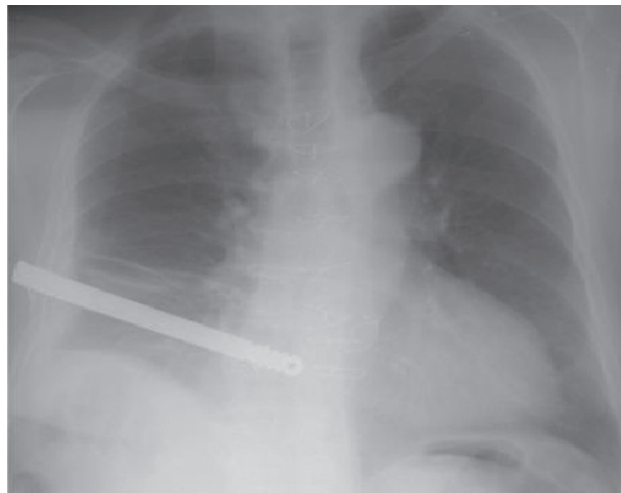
The postoperative posteroanterior chest x-ray of the patient.
